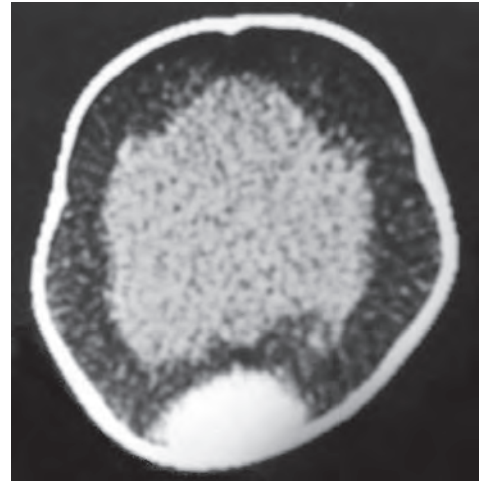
CT ventriculogram in a patient with hydrocephalus
